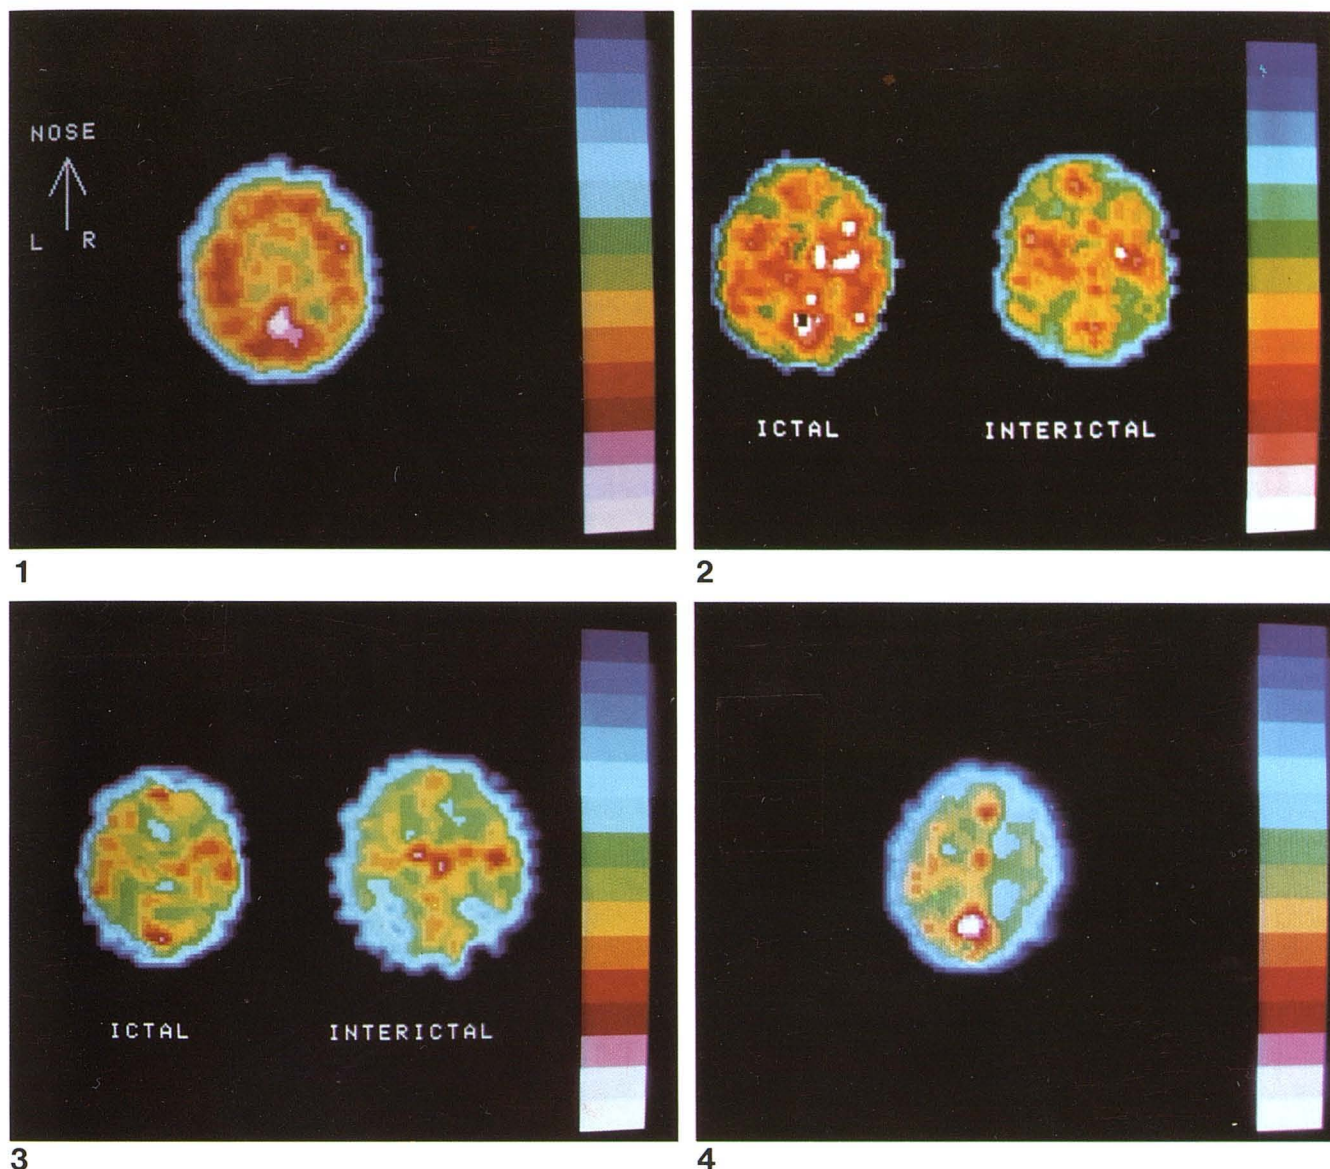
SPECT rCBF study of normal, 40-year-old volunteer. (Orientation on left applies to figs. 2–4 also.)
